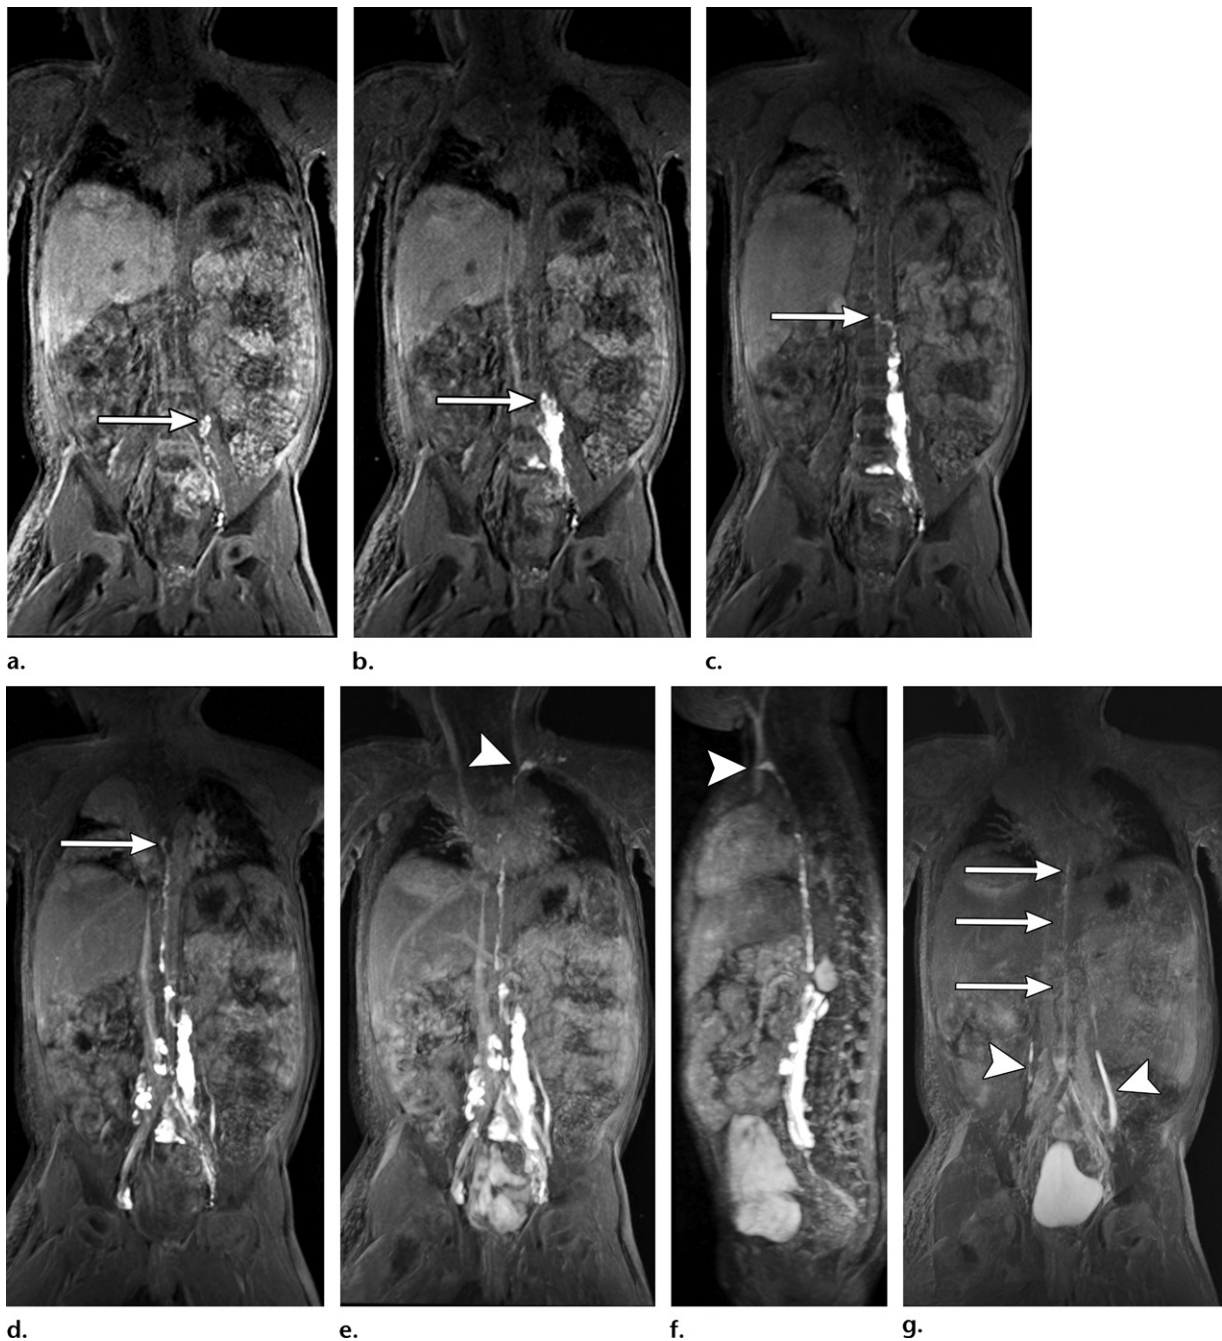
First passage of contrast material after groin intranodal injection up to the venous angle in a 2-year-old child with protein-losing enteropathy and areas of lymphedema in the extremities. CCLs were interpreted to be normal in this child. (a–e) Coronal 3D T1-weighted images with thin MIP reconstruction at 2 (a), 4 (b), 6 (c), 8 (d), and 11 (e) minutes after injection of contrast material demonstrate progressive passage of the contrast material (arrow) up to the venous angle (arrowhead in e). (f) Sagittal oblique MIP reconstruction from the 14-minute acquisition demonstrates the entire CCLs and the venous angle (arrowhead). (g) Coronal 3D T1-weighted image with thin MIP reconstruction at 30 minutes after contrast agent injection demonstrates almost complete washout of contrast agent from the CCLs (arrows) with excretion in the ureters (arrowheads) and urinary bladder.
